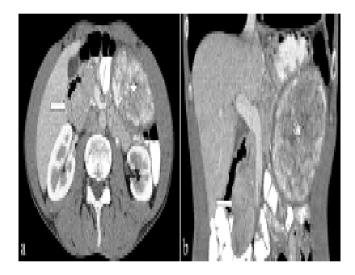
Contrast-enhanced CT images (axial (a), coronal (b)); gossypiboma (star), solid mass (NET) lesion (arrow).
